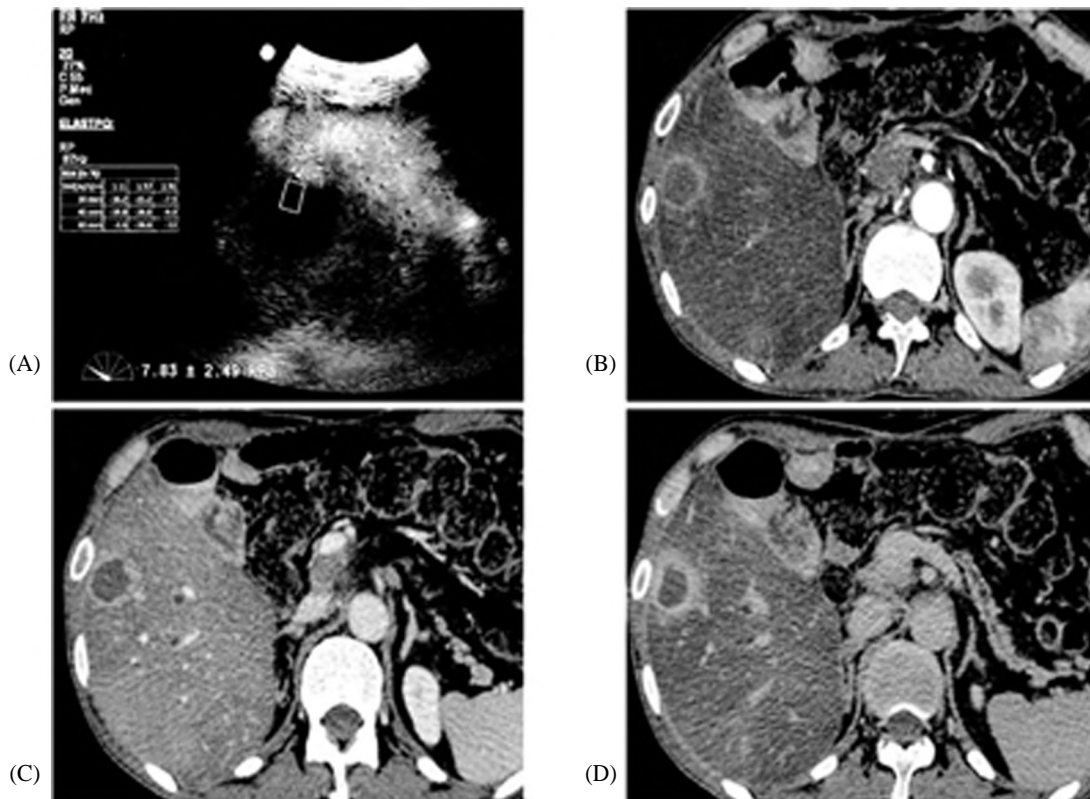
(7): Cytologically proven liver abscess with suppurative inflammation. A 57 year old male with history of Whipple operation 7 months ago due to cancer head of pancreas, under chemotherapy, now presents with multiple hepatic focal lesions, likely metastatic deposits. (A) B-mode shows a well-defined hypoechoic focal lesion with SWE mean stiffness value (7 ± 2 kpa). (B-C-D) Axial Triphasic CT arterial (B), Portal (C) and delayed phases (D) Display ring enhancement in all phases.
